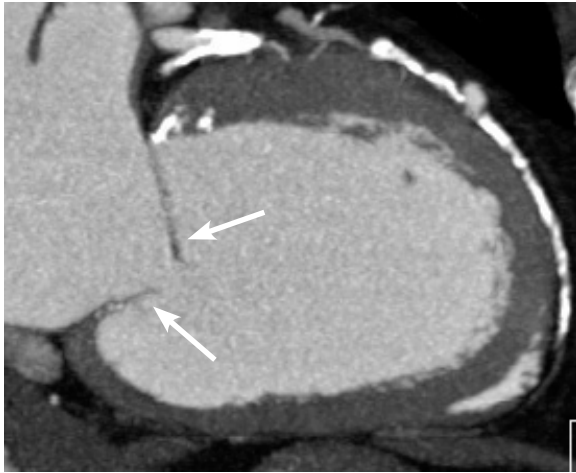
Multi-planar reconstruction of a 16-slice cardiac CT examination along the long axis of the heart through the mitral valve plane. The increased spatial resolution of 16-slice CT enables improved visualization of the mitral valve flaps (arrows) compared to 4-slice CT
